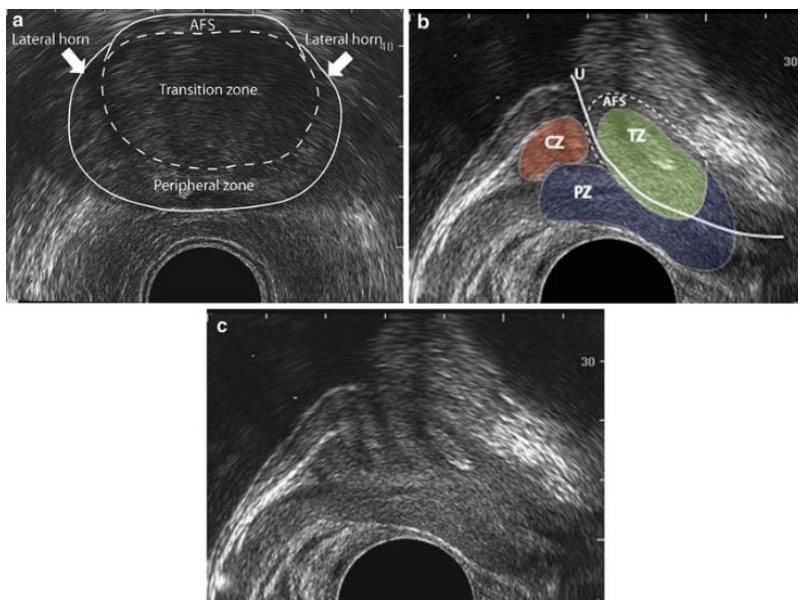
Transrectal sonograms of the prostate (a) shows axial representation of the zonal anatomy and shows anterior fibromuscular stroma (AFS) anteriorly. (b and c) shows the zonal anatomy of the prostate in the sagittal plane. U urethra; CZ central zone; TZ transition zone; PZ peripheral zone; AFS anterior fibromuscular stroma (1).
